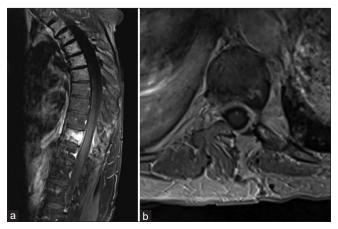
(a) Four-month postoperative sagittal T1-weighted magnetic resonance imaging (MRI) with contrast demonstrating good spinal cord decompression with removal of epidural tumor components. Residual enhancement is seen throughout the T10 vertebral body which was not pursued during surgery. (b) Postoperative axial T1-weighted MRI with contrast showing the hemilaminectomy defect and a well-decompressed spinal cord with normal positioning in the spinal canal.
